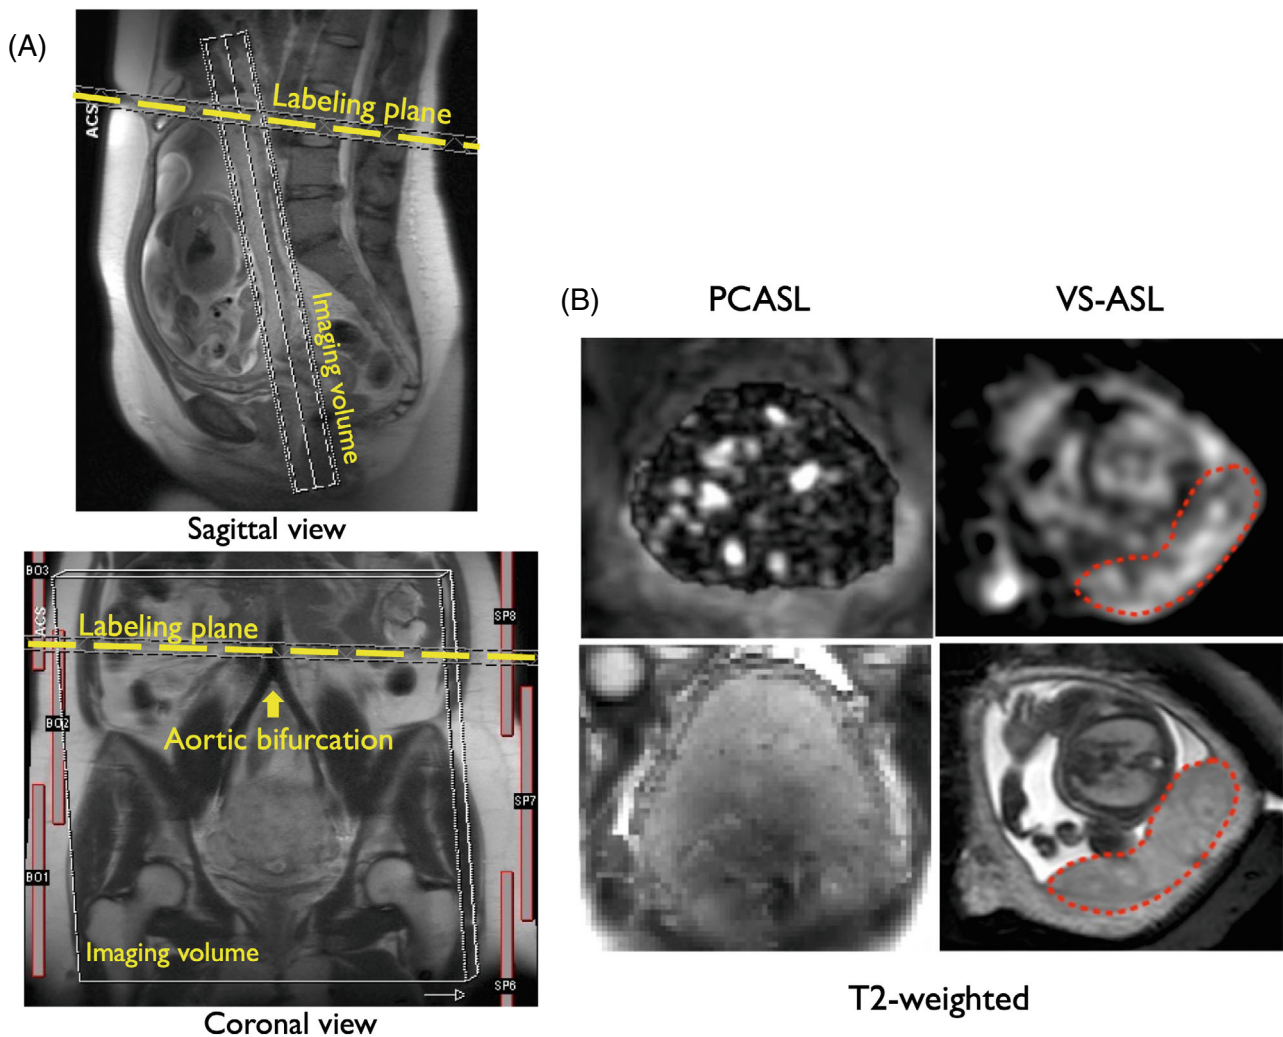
(A) Placenta PCASL planning. (B) ASL images acquired using PCASL and VS-ASL (top) and corresponding T2-weighted anatomical images (bottom) modified from Shao et al. 2018 and Zun et al. 2017 (reproduced under a Creative Commons Attribution 4.0 International License - <http://creativecommons.org/licenses/by/4.0/>)
